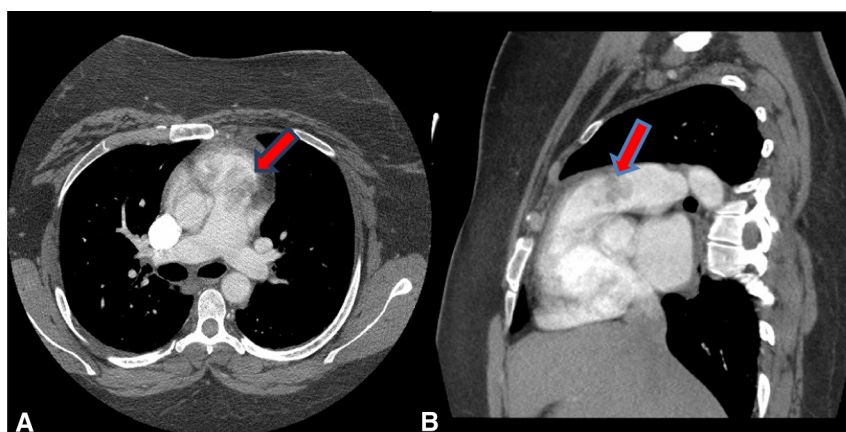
Computed tomography demonstrating an intravascular mass of the pulmonary artery near the valve (red arrows) as seen on transverse (A) and sagittal (B) views.
